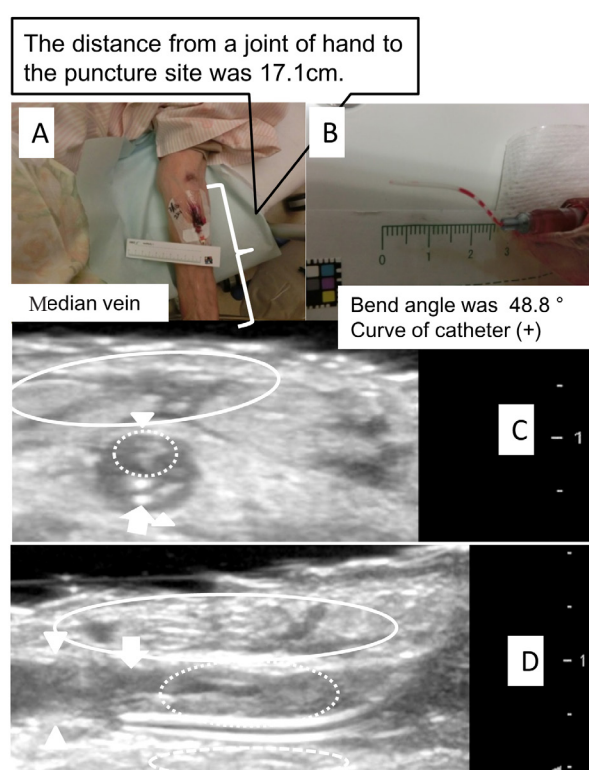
Upper arm vein (non-CF): Case 16202. (A) Upper arm insertion site. (B) Bend angle. (C) Ultrasound image before catheter removal (transverse image). (D) Ultrasound image (longitudinal image). Ultrasound images showing vessel wall (arrowheads), catheter tip (arrows), and thrombus (dotted circle).
